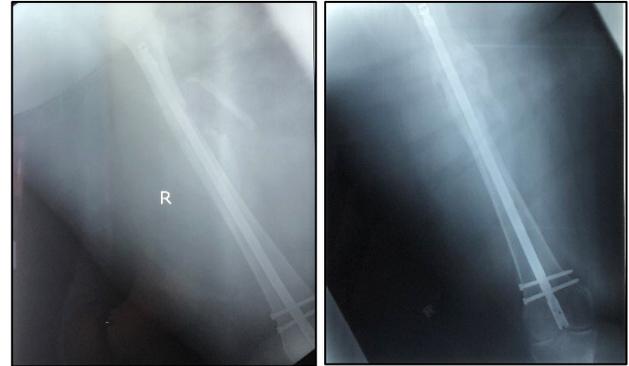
Plain Radiograph of Right Femur Post-operative 1 week (left) and 8 months (right)
